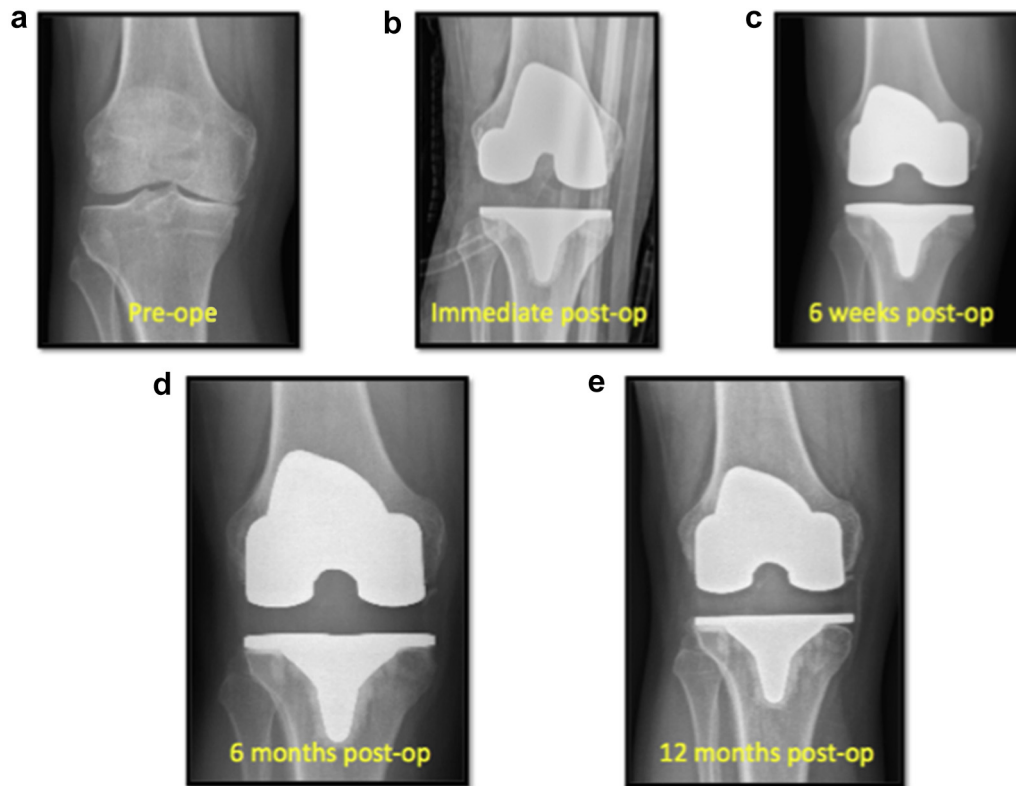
Case Example 1. Patient is a 50-year-old male who underwent a right primary total knee arthroplasty. Preoperative and immediate postoperative images are shown revealing correction of his previous varus deformity (a,b). Radiographs from his 6-week (c), 6-month (d), and 12-month postoperative visits (e) show development of Grade 1 resorption at 6 months, with progression to Grade 2 at 12 months.
